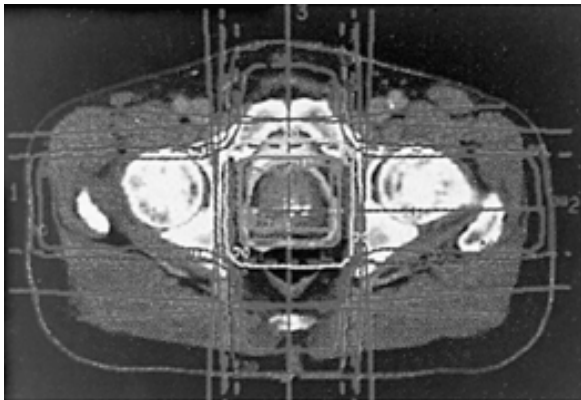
Example of a computed tomograph-based treatment plan in a patient with prostate cancer. This technique in concert with computer-assisted image analysis greatly enhances the accuracy of external beam radiotherapy. (From Lichter AS, Lawrence TS. Recent advances in radiation oncology [Review]. *N Engl J Med* 1995;332:371, with permission.)
